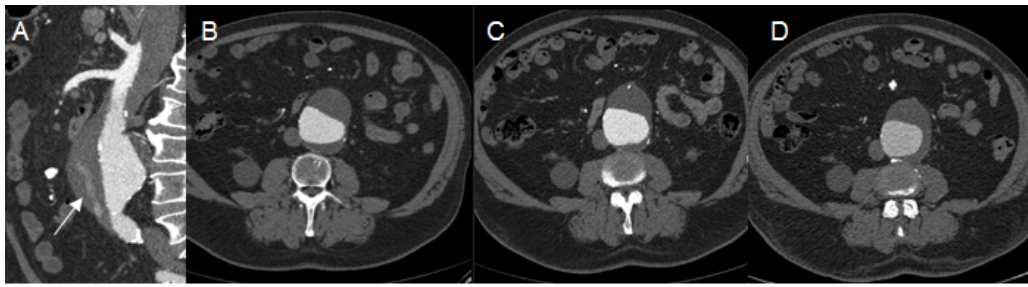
CT angiography of the post-dissection infrarenal aneurysm in the sagittal plane showing the filling of the false lumen (a), transversal slide of a CT angiography of the post-dissection infrarenal aneurysm before treatment (b), one month postoperatively (c) and 8 months postoperatively (d).
